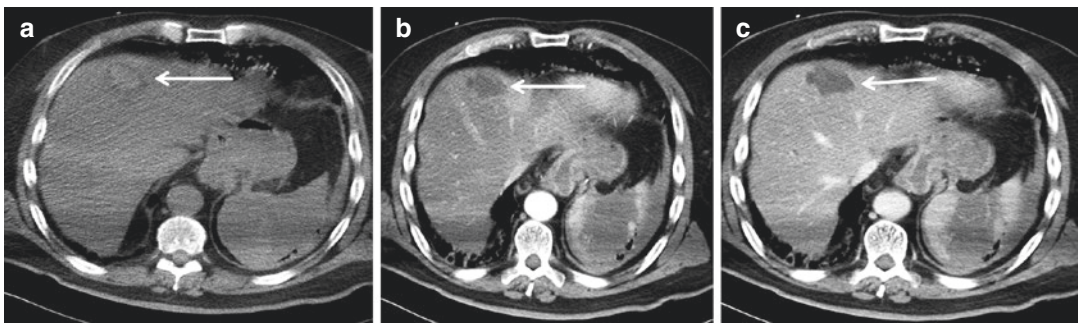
(a) CT scan without contrast media administration, (b, c) CE-MDCT scan in arterial (b) and in venous phase (c) depict a parenchymal hematoma. The hematoma
